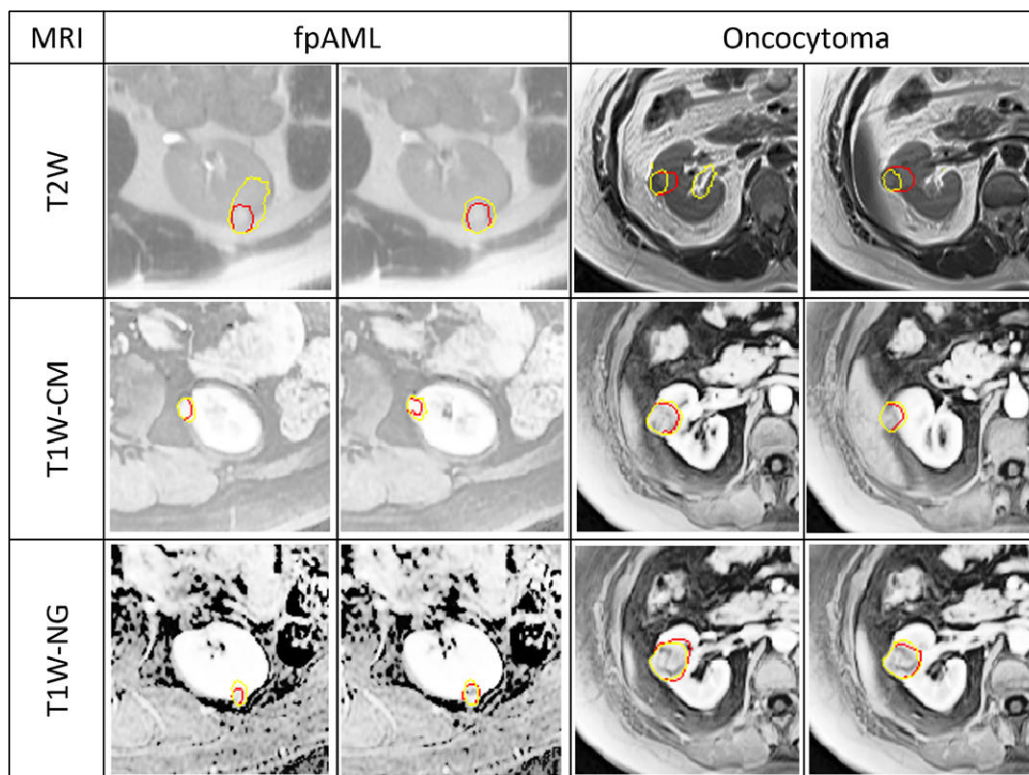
Sample benign fat poor AML and oncocytoma detection on 3 MRI sequences where algorithm-generated contours are in red and manual segmentation is in yellow.
